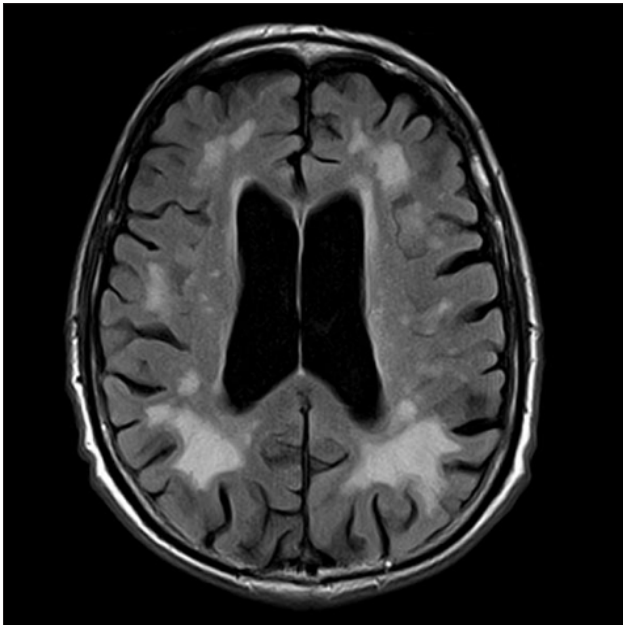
MRI scan showing white matter small vessel ischemic change and microhemorrhages.
